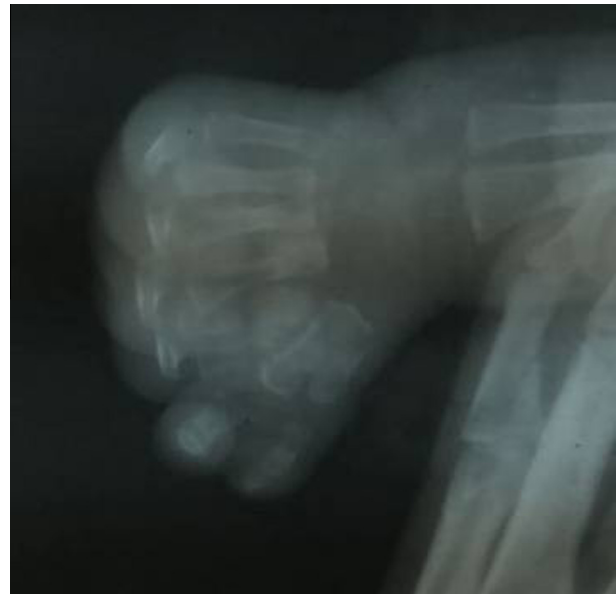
X-ray of the right hand.
